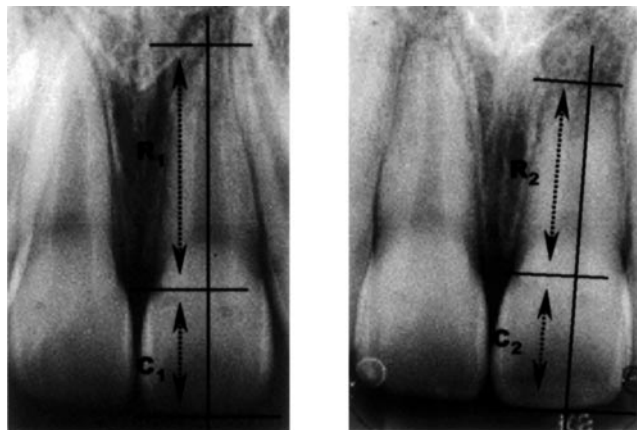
Measurements on pre- and post-treatment radiographs (C_1 = crown length on pre-treatment radiograph, R_1 = root length before treatment, C_2 = crown length on post-treatment radiograph, R_2 = root length after treatment).
